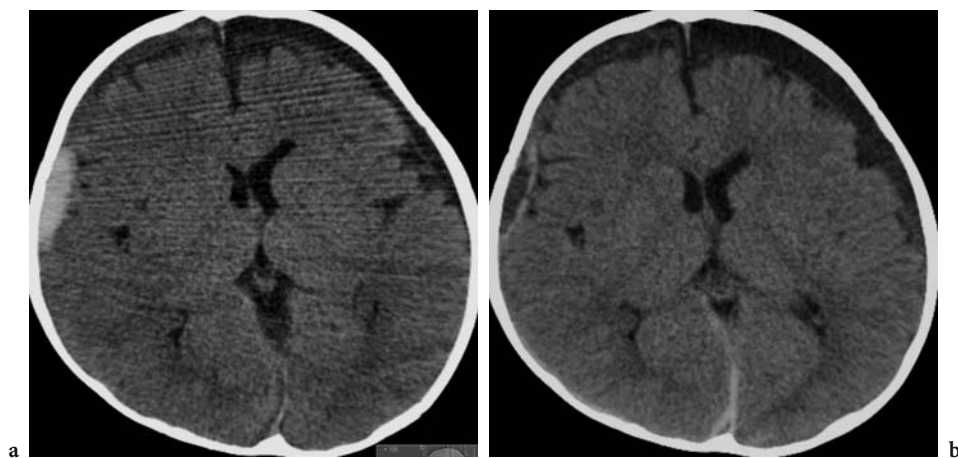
Influence of decreasing the voltage on the quality of a brain CT in a 1-year-old child with subdural haematomas of variable age. a Scan at 120 kV, 250 mAs, $CTDI_{Vol}$ of 45 mGy, DLP of 688 mGy-cm, estimated effective dose of 4.8 mSv. b Scan 2 days later at 100 kV, 330 mAs, $CTDI_{Vol}$ of 43 mGy, DLP of 613 mGy-cm, estimated effective dose of 4.3 mSv. Note the markedly improved contrast in this follow-up scan despite a slightly lower effective dose
